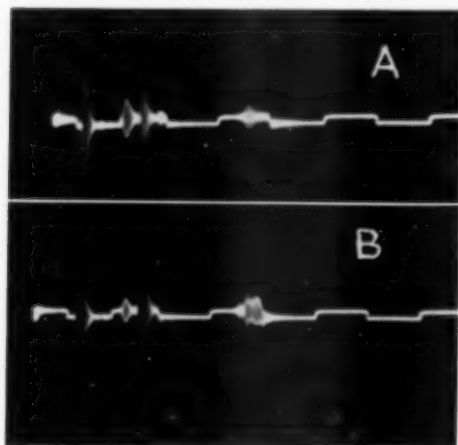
(Mundt and Hughes). Ultrasonic tracings of two normal human eyes.
